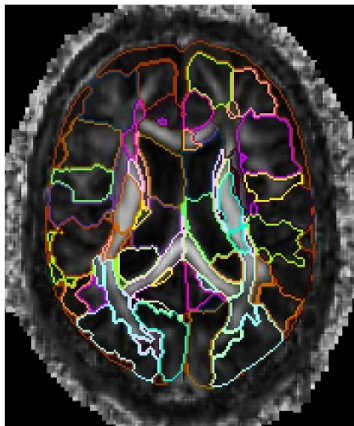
Highest level of granularity from FA map in MRI-cloud, 168 ROIs
